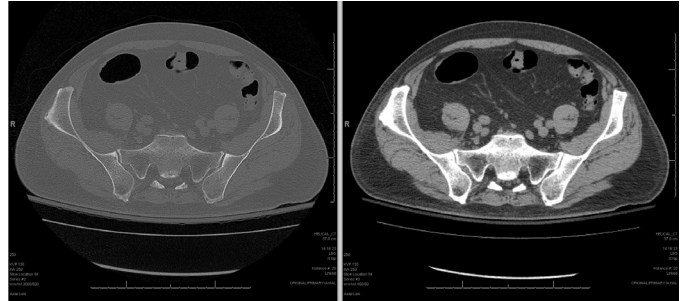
CT scan of the pelvis does not show any radio dense or radiolucent lesions or irregularity at the Sacroiliac joint.
